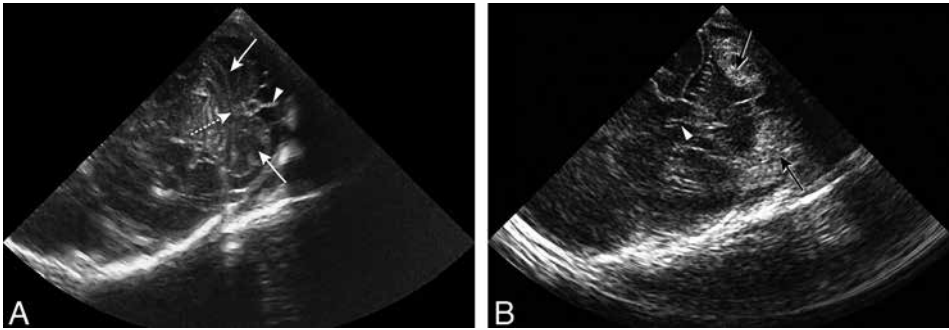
Coronal ultrasound scans in two very preterm infants (gestational age respectively 29 and 26 wk), using the mastoid fontanel as acoustic window. (A) Normal appearing cerebellar hemispheres (arrows), cerebellar vermis (dotted arrow) and cisterna magna (arrowhead). (B) Echogenic lesions in both cerebellar hemispheres (black arrows), representing hemorrhages. Also showing the aqueduct (arrowhead).
